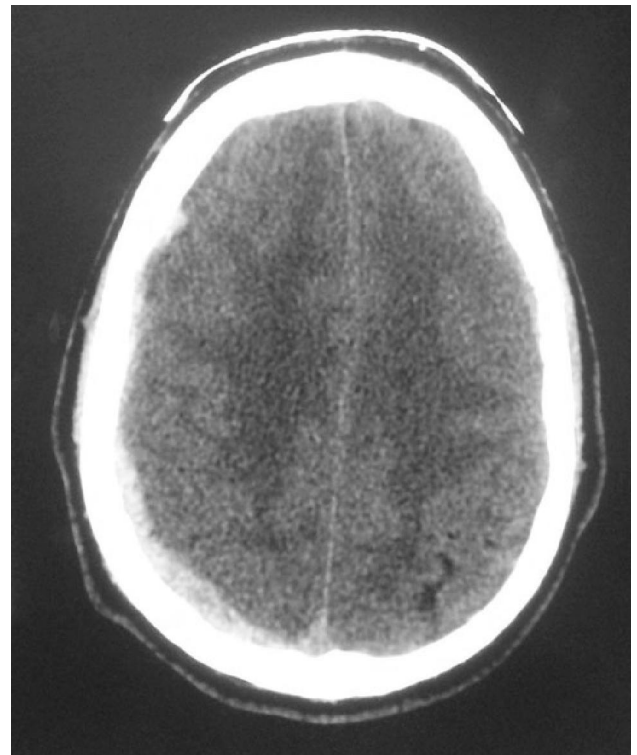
CT scan brain showing small hyperdense subdural hematoma along right cerebral convexity
